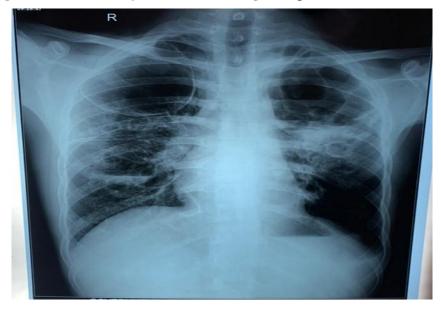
Chest X-ray PA view showing multiple thick walled cavities
